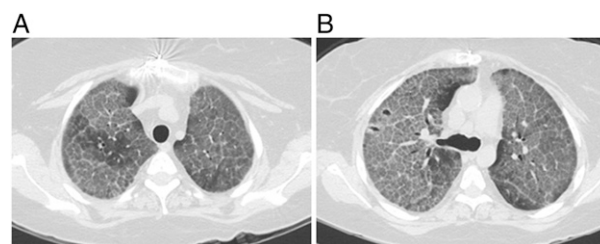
A, B, Different slices from a CT scan of the chest demonstrate diffuse ground-glass infiltrates with alveolar septal thickening.
